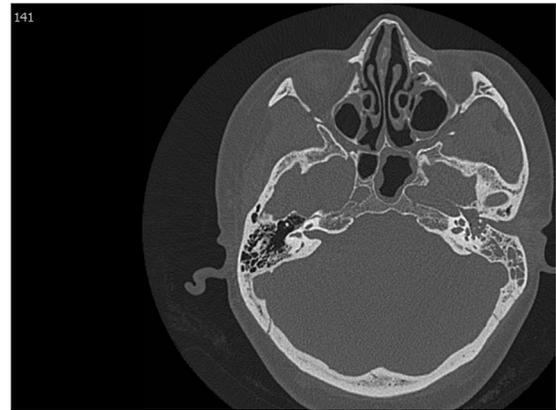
CT temporal bone showing no evidence of bony destruction or intracranial complications.
